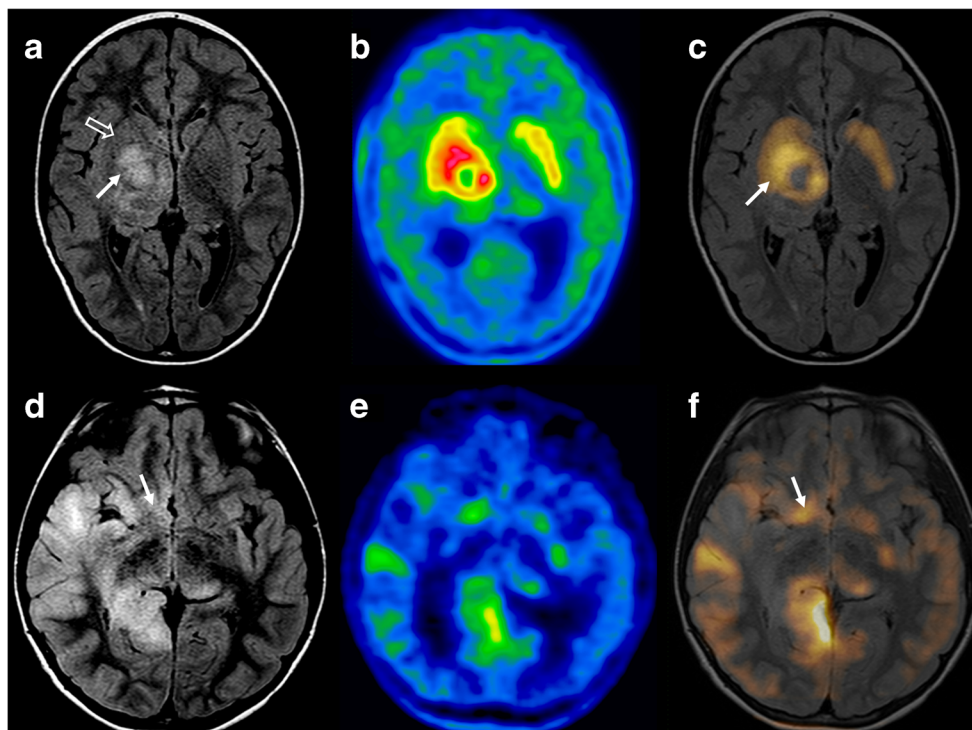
False-positive and false-negative ^{18}F -DOPA PET/CT images. a–c Glioblastoma multiforme (patient 24). The axial FLAIR image (a) shows a right thalamic lesion with involvement of the ipsilateral internal capsule and globus pallidus (*thin arrow*). There is no evidence of involvement of the ipsilateral putamen on MRI (*open arrow*). The ^{18}F -DOPA PET/CT image (b) shows increased uptake with a modified right striatal outline (discrimination between the globus pallidus and the putamen is not possible). The fused PET/MRI image (c) demonstrates increased uptake only in the lesion involving the right globus pallidus (*arrow*) with physiological uptake in the right putamen. d–f Anaplastic astrocytoma (patient 9).
